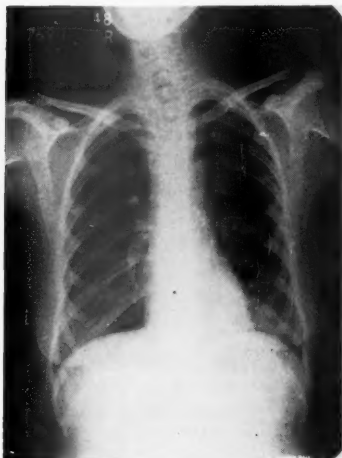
Chest roentgenogram taken 12 days before admission to the hospital showing a generalized emphysema with depression of both diaphragms and widening of the intercostal spaces. These radiologic findings strongly suggested the previously established diagnosis of bronchial asthma.
